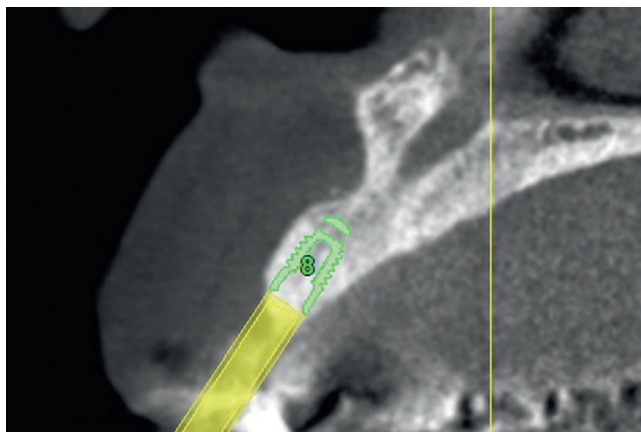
Cone-beam computed tomography image made after grafting showing proposed implant placement.
